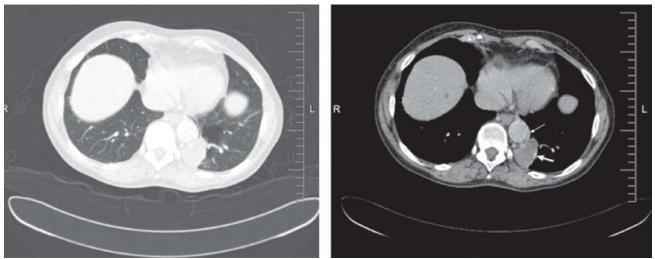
Lung (left) and mediastinal (right) windows of the computed tomographic images demonstrating feeding artery originating from aorta (thin arrow) and intralobar sequestration in the left lower lobe (thick arrow).
